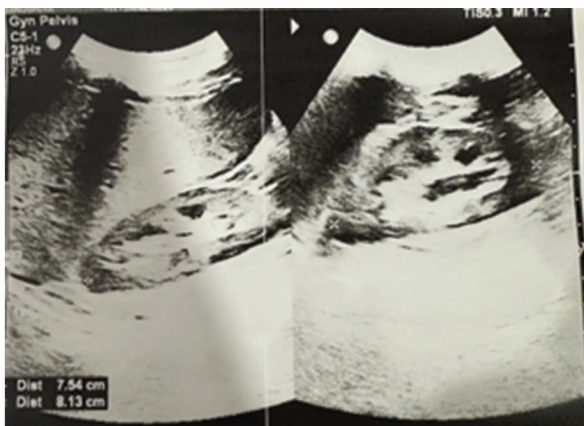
Pelvic sonogram showing bilateral massively enlarged ovaries (>70ml in volume) with multiple large cysts of varying sizes
